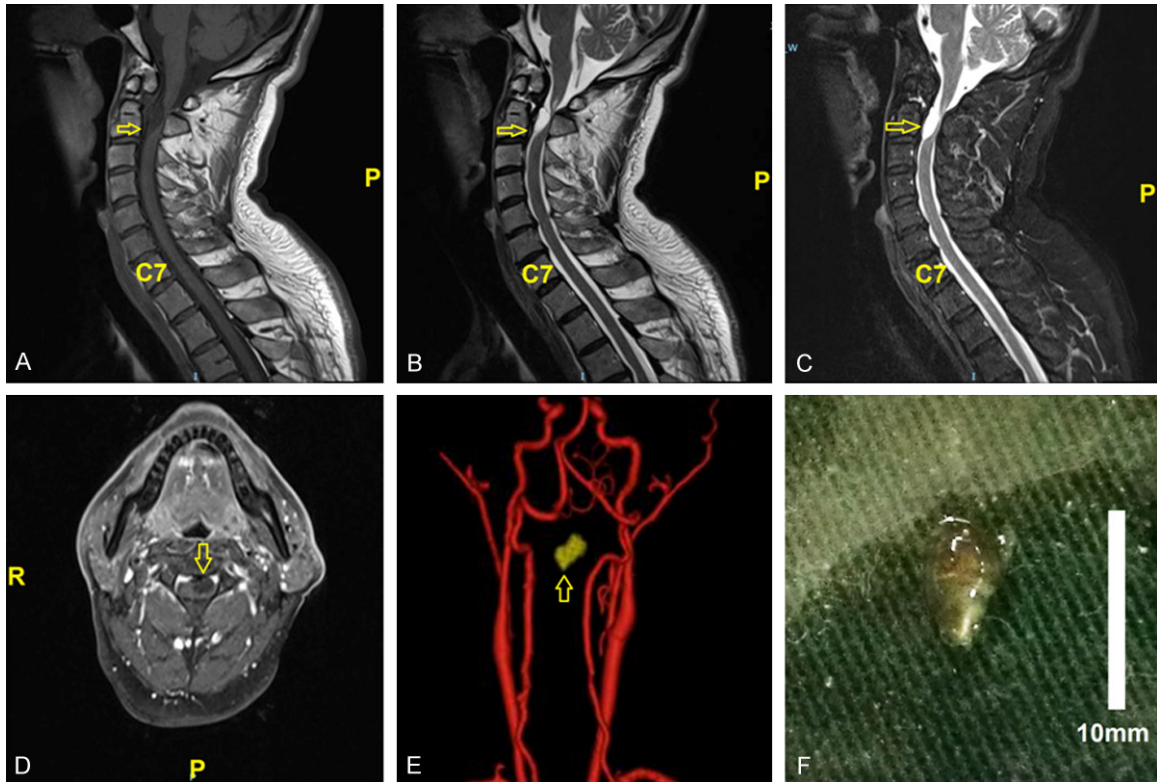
MRI scan of the cervical colloid cyst shows in the front left of the intramedullary level spinal cord of neck 2, irregular long T1 (A) and long T2 (B) signal shadow can be seen. Fat saturation sequence signal was high (C). The corresponding level spinal cord narrowed significantly after oppression and shifted to the right (D). There is no obvious blood vessel around the tumor (E). 0.6 ml of cyst fluid was extracted, which are colorless transparent gel (F). The yellow arrow points at the tumor, P points at the rear side and R points at the right side.
